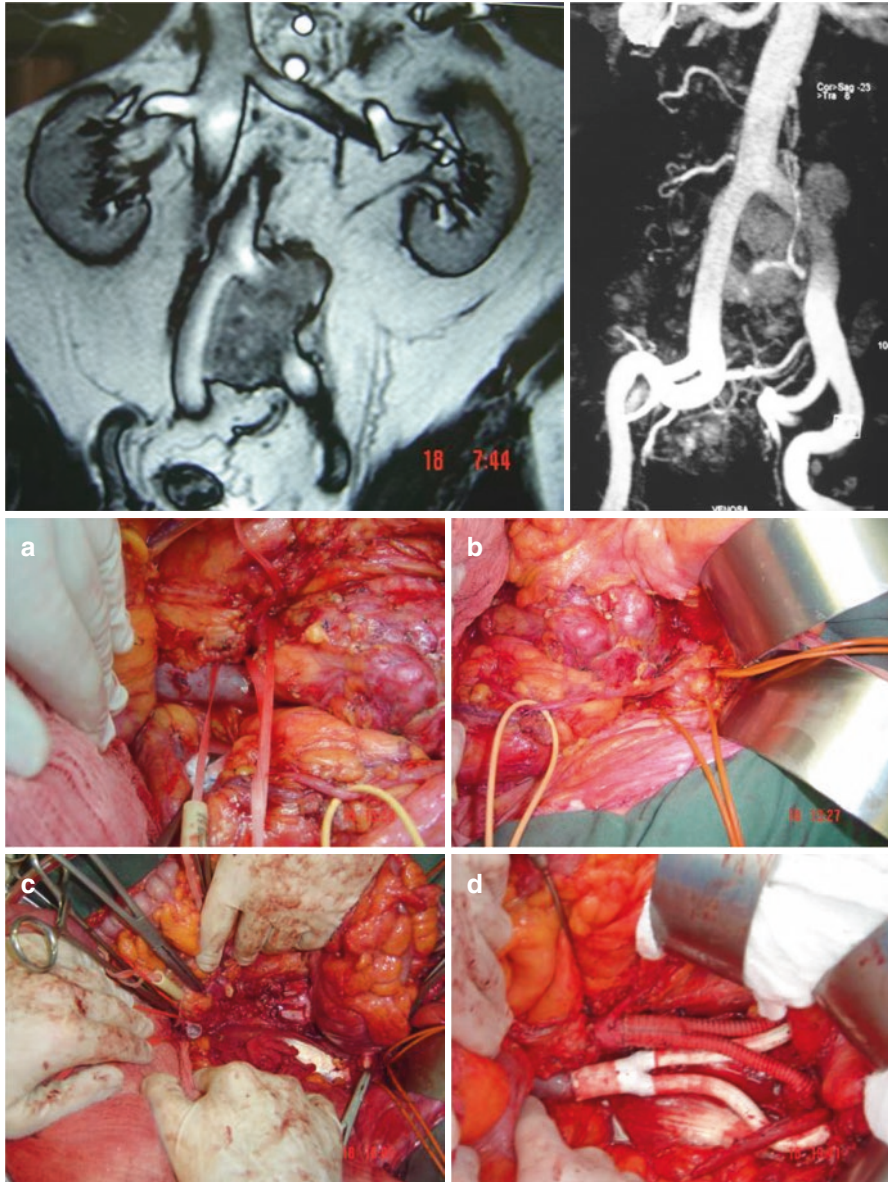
A 68-year-old male patient with retroperitoneal pleomorphic sarcoma. MRI shows vascular involvement at the bifurcation of the aorta and at the confluence of common iliac veins. The surgery was jointly scheduled by the oncology and vascular surgery teams. In this case, the option was to precede the resection without doing a temporary “by-pass.” During the resection phase, however, there was a significant bleeding, which was only adequately controlled after the reestablishment of the venous flow. (a) Isolation and proximal repair of the aorta, vena cava, and ureters. (b) Isolation and distal repair of the external iliac vessels bilaterally. (c) Operative bed after “en bloc” resection of the tumor with a segment of the aorta and common iliac arteries and a segment of the inferior vena cava and common iliac veins. (d) Arterial reconstruction with bifurcated Dacron prosthesis and venous reconstruction with bifurcated PTFE prosthesis. (Fábio Ferreira, surgical oncology and Kenji Nishinari, vascular surgery)
